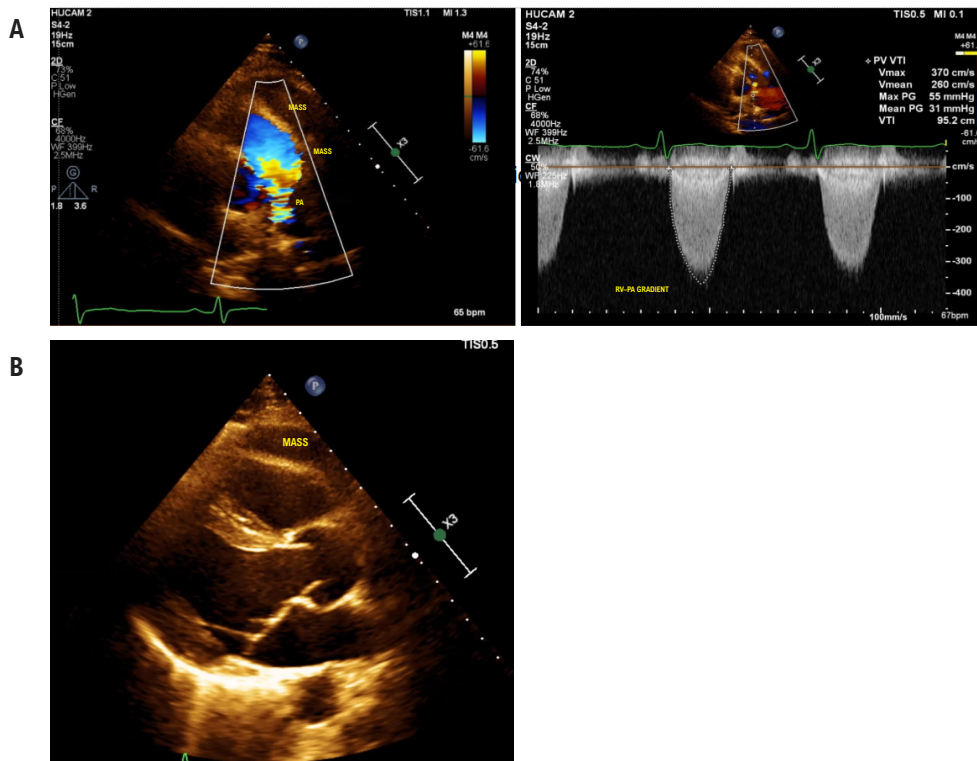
A) Mediastinal mass and pulmonary valve gradients showing reduction. B) Parasternal long-axis view, showing reduction of the mass in the mediastinum. PA: pulmonary artery; RV: right ventricle.
